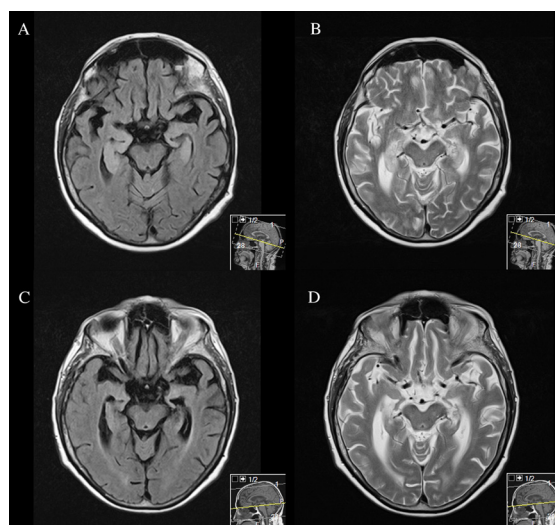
Axial MRI brain scans showing medial temporal signal change on FLAIR (A) and T2 (B) images shortly after admission. Ten weeks later signal changes had resolved but atrophy was present on follow-up MRI brain scans (C and D).
